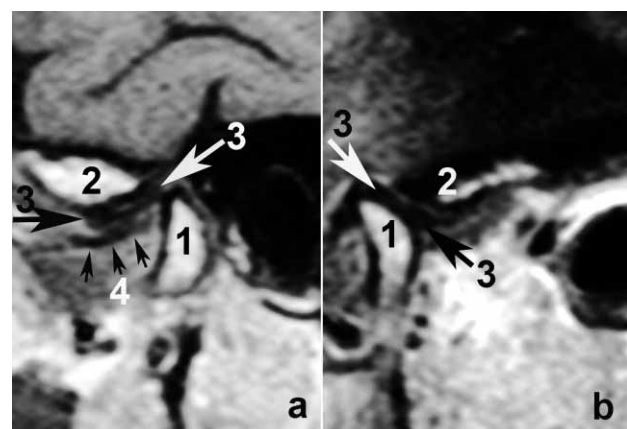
MRI showing left TMJ with disc displacement (a, closed mouth) with reduction and with condylar hypermobility (b, open mouth) (1, condyle; 2, articular eminence; 3, disc; 4, musculus pterygoideus lateralis).
